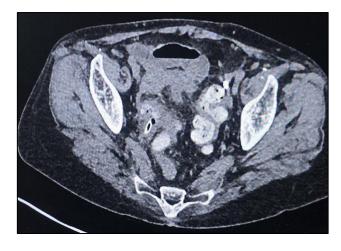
CT scan of sigmoid perforation with a arrow pointing at the foreign body.
